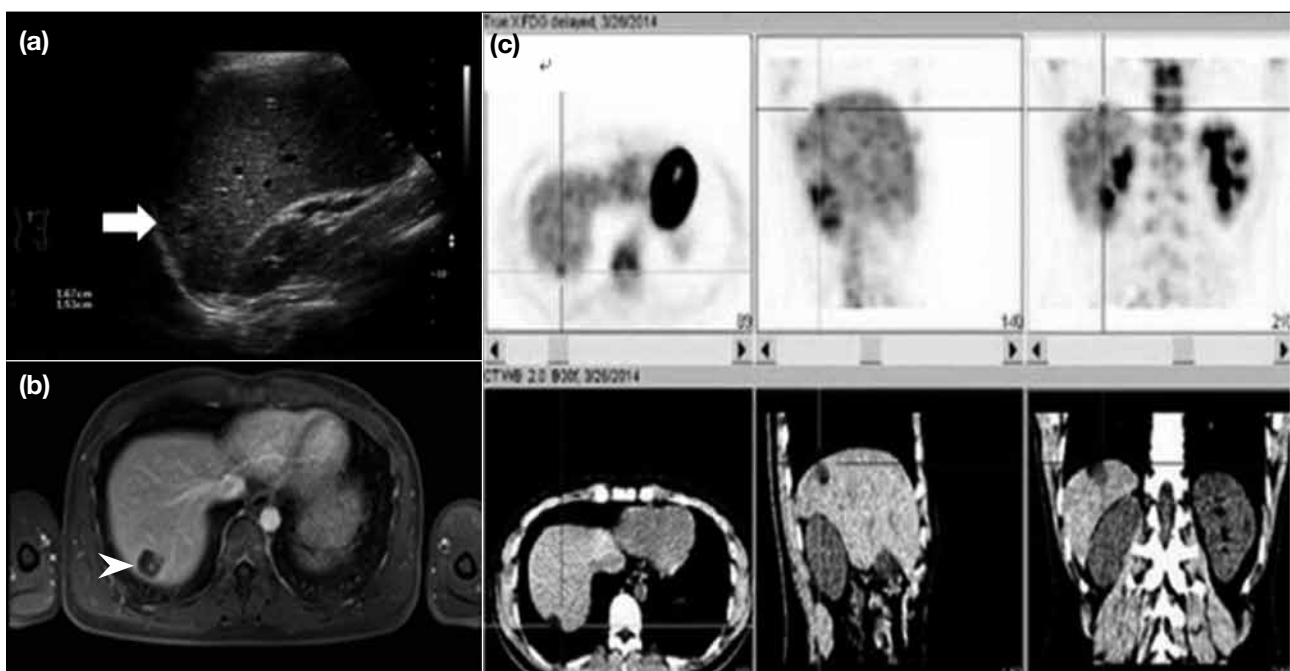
(a) Ultrasound: solid component is present within segment 7 cystic lesion (white arrow). (b) Magnetic resonance imaging: axial T1-weighted post-contrast image shows mildly enhancing soft tissue within the cystic lesion (white arrowhead). (c) Positron emission tomography-computed tomography: low level of 18 fluoro-2-deoxy-D-glucose uptake is detected within the lesion.
